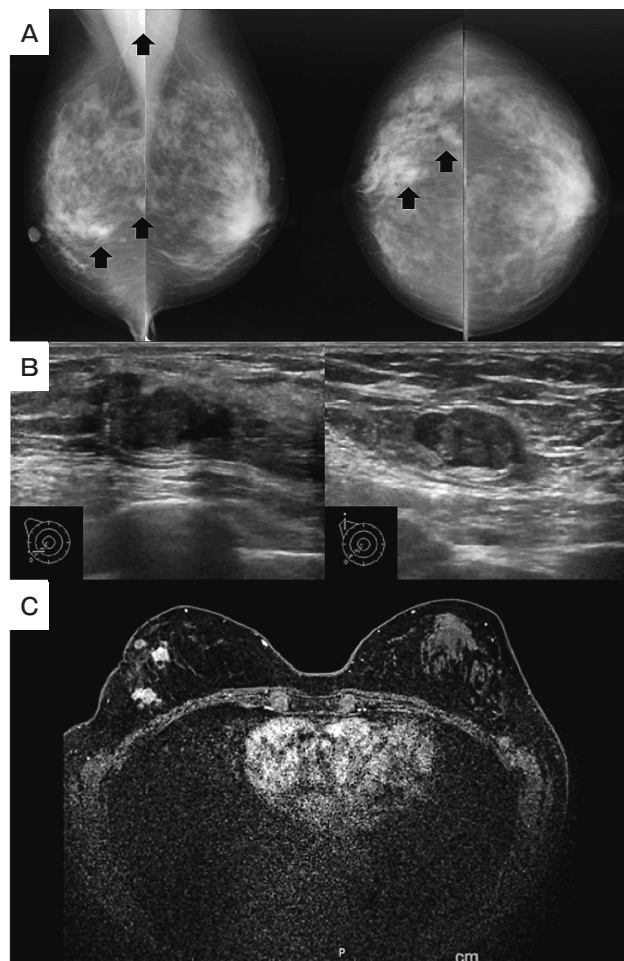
Additional imaging findings. A, Mammography showed an enlarged right axillary lymph node and FAD (black arrows) in the right M-O region; B, Breast ultrasonography showed an irregular hypoechoic mass 1.6 cm in size at the 7 o'clock position and enlarged lymph nodes in the right axilla; C, CE-MRI revealed multiple contrast-enhanced nodules on the lower outer side of the right breast.
